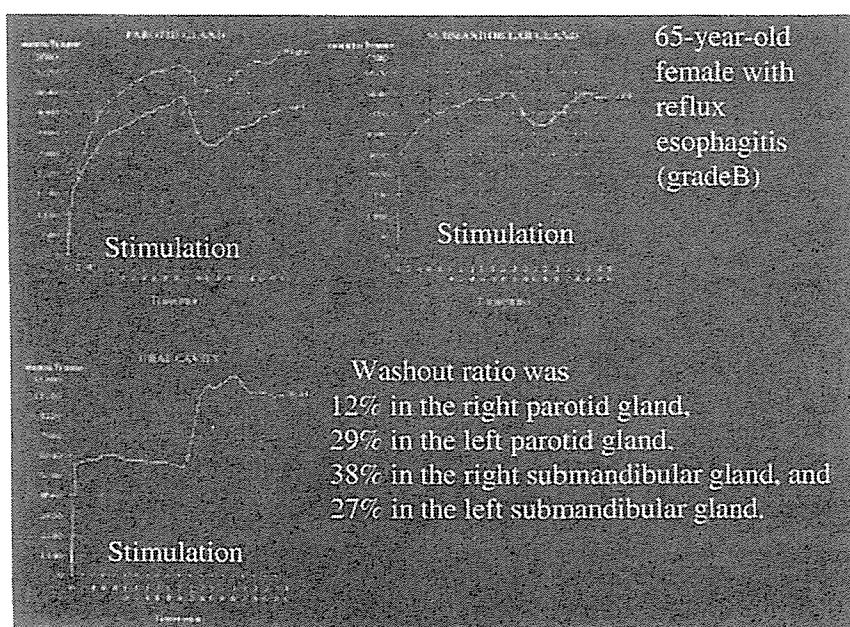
A representative time-activity curve generated from salivary scintigraphy in patients with grade B reflux esophagitis.
